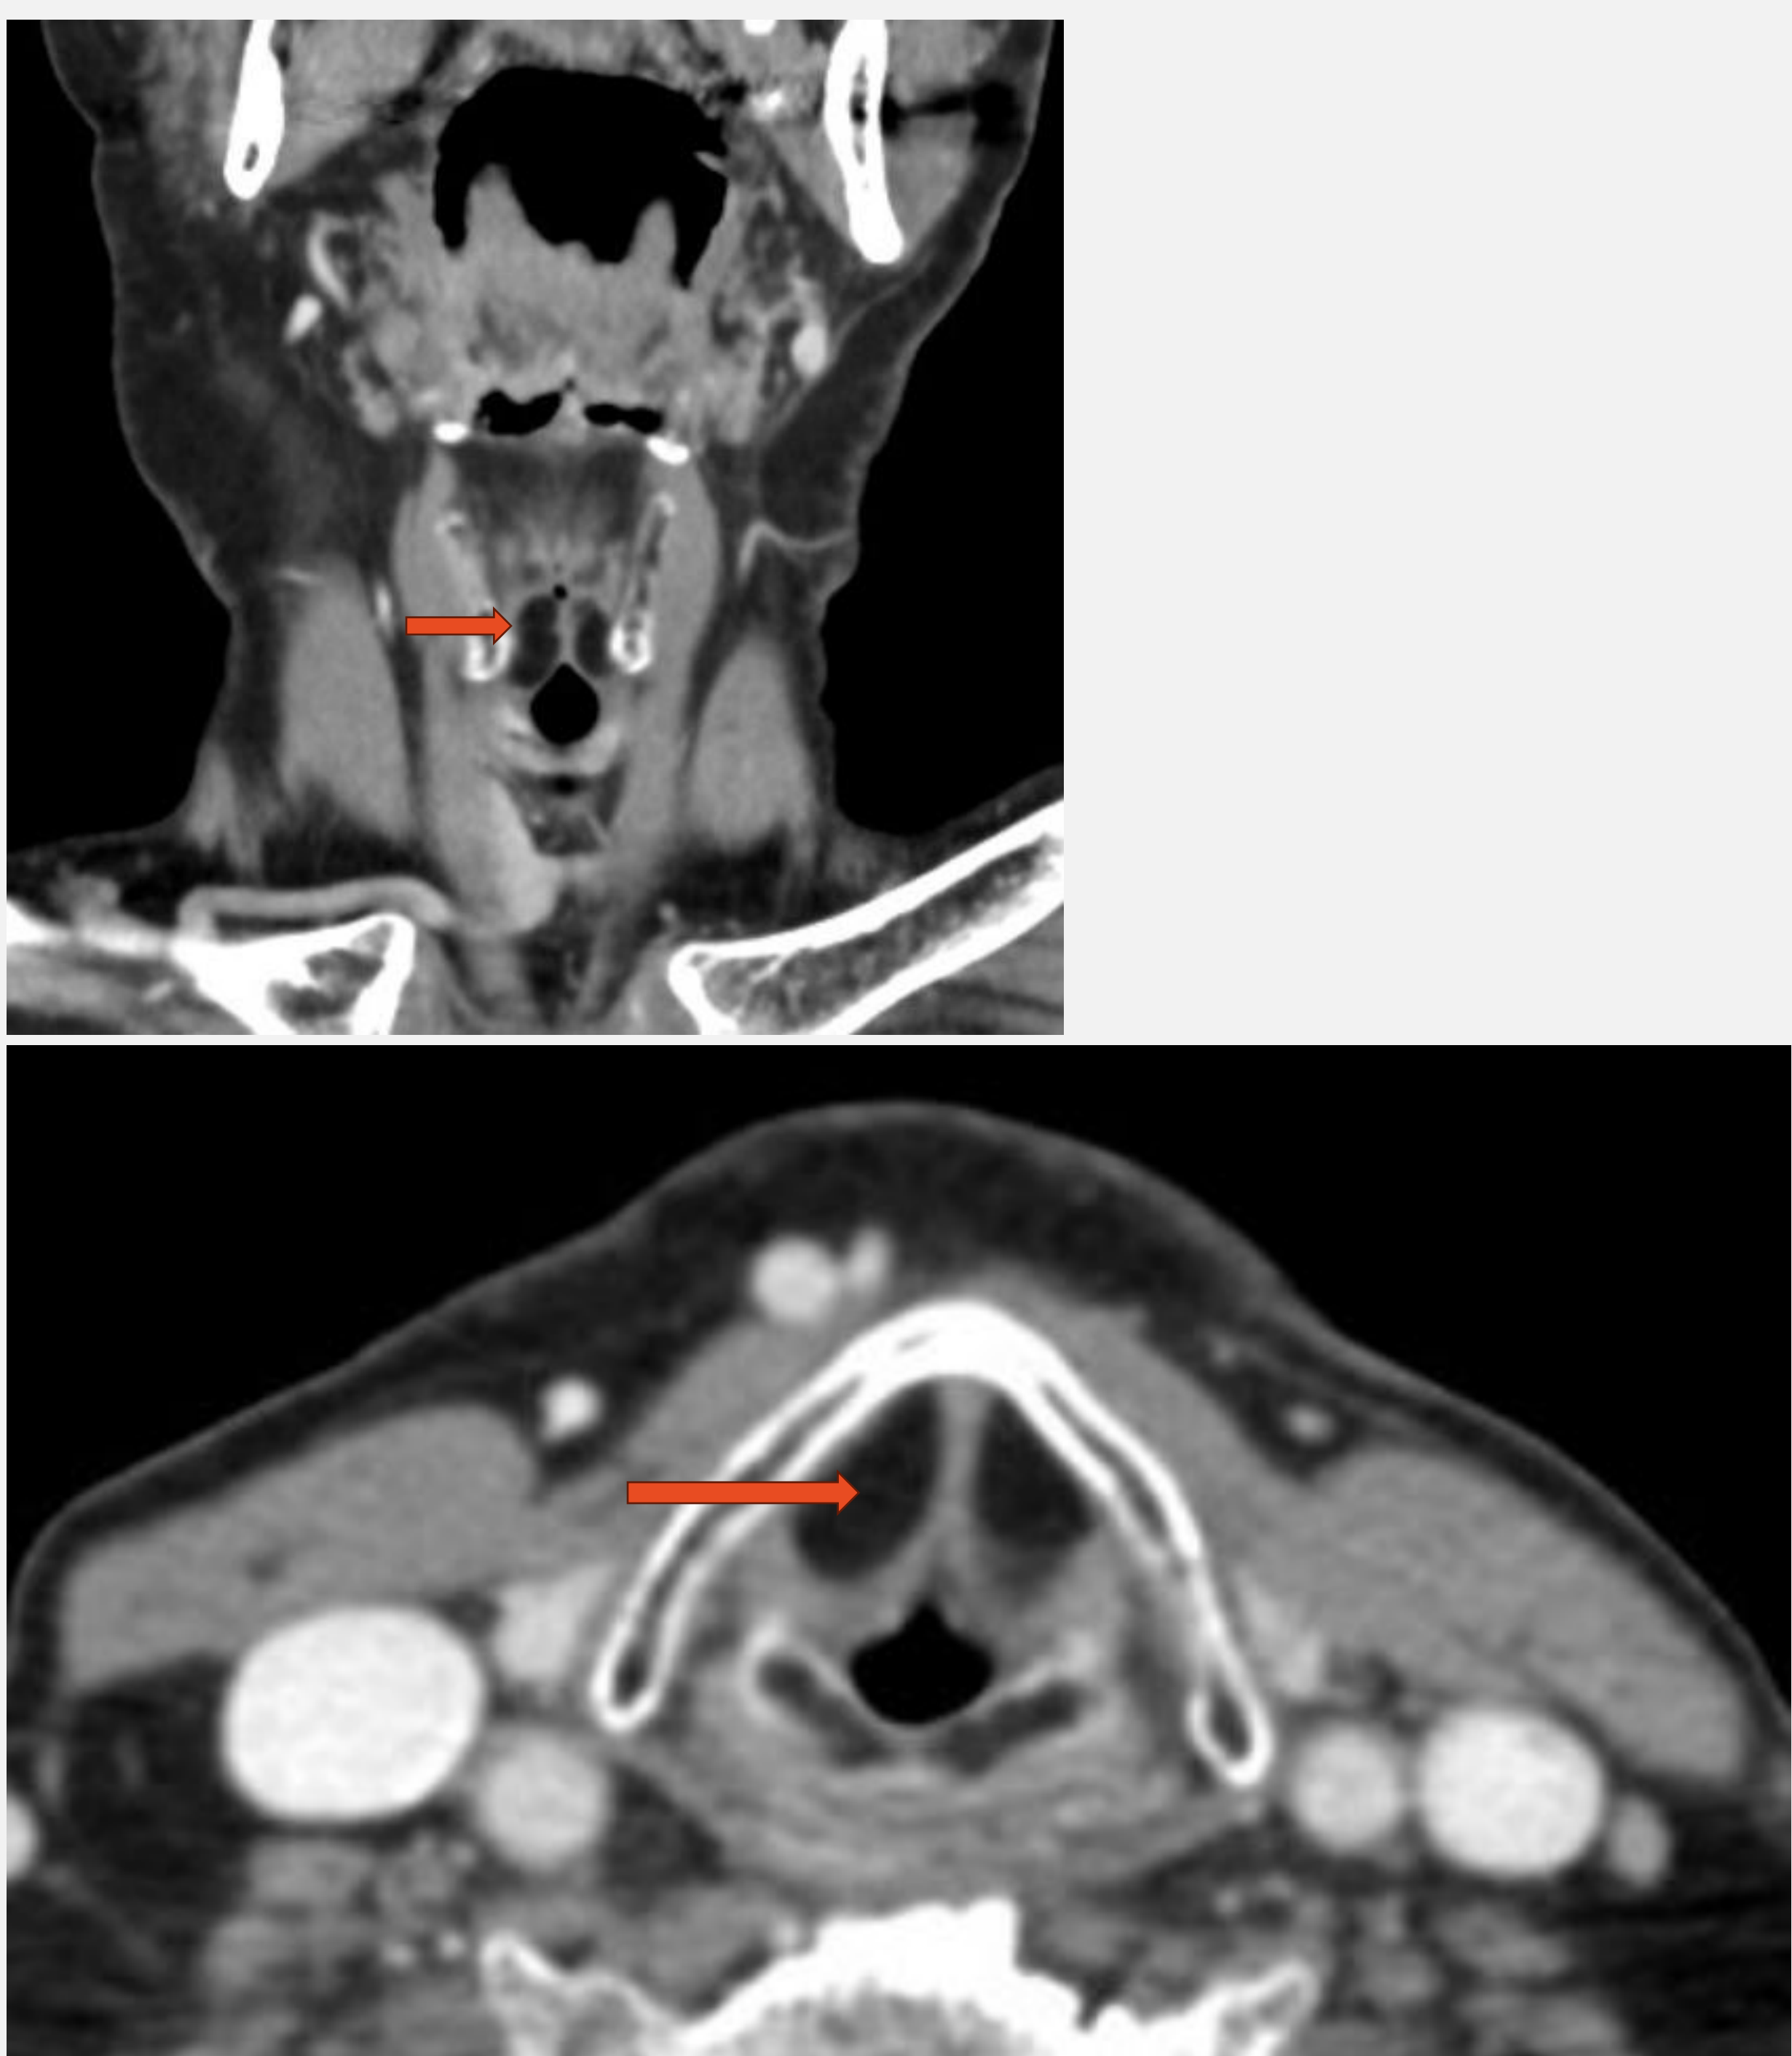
CT images from the preoperative workup. Note the fat marked by red arrows
